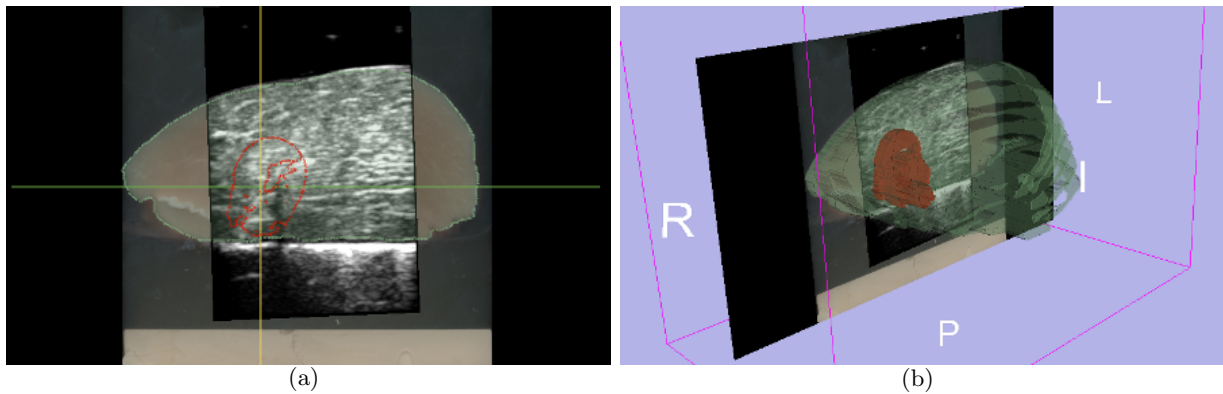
(a) Ablated zone in an ultrasound slice is shown in 3D Slicer. (b) Ablated region is reconstructed in 3D using volume compounding technique.
